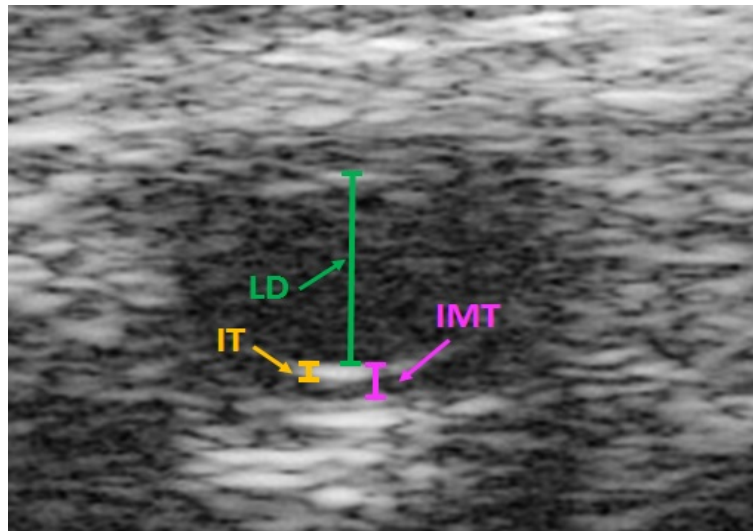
UHFUS image of an artery acquired by the Vevo 2100 ultrasound scanner. Measurements shown are the Intimal Thickness (IT), Intima-Media Thickness (IMT), and the Lumen Diameter (LD)
